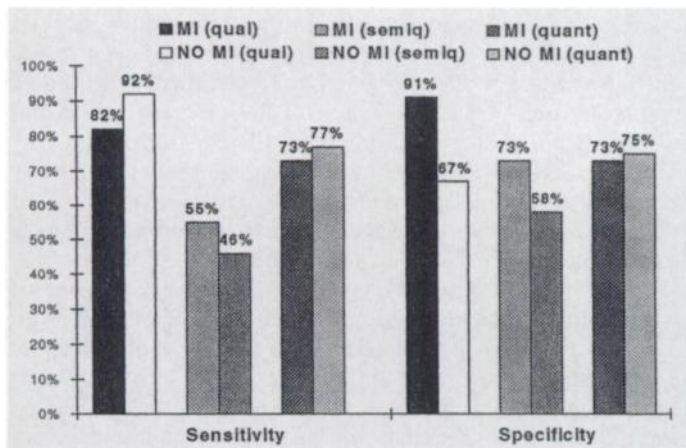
Sensitivity and specificity of qualitative, semiquantitative and quantitative analysis of ^{99m}Tc-sestamibi SPECT for detection of restenosis in patients with or without prior myocardial infarction.
